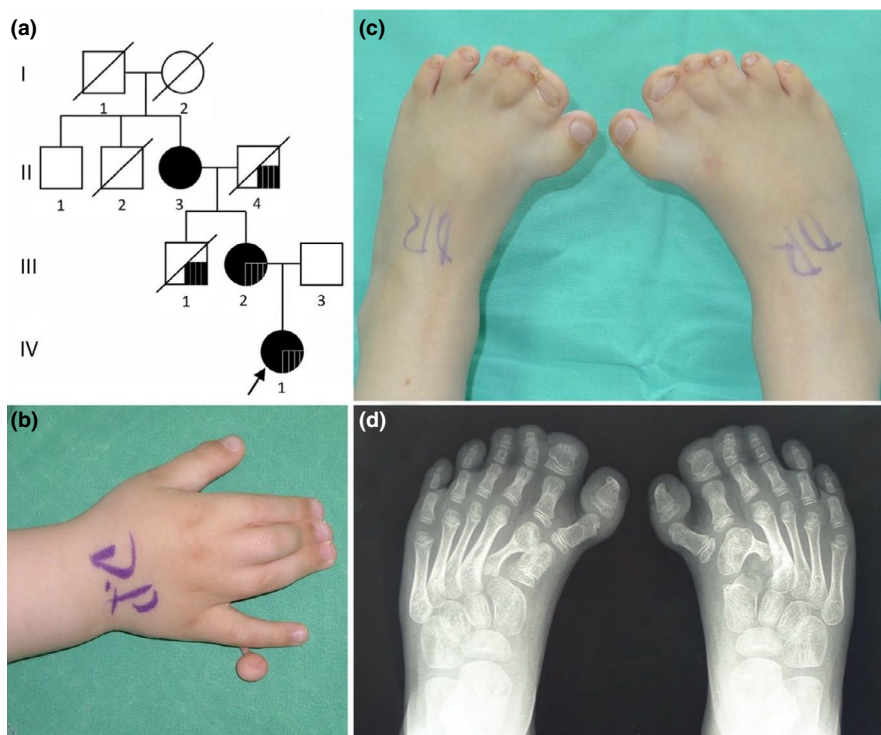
(a) Genealogy of the family. Black symbols denote patients with analyzed variants in *GLI3*. Black square in II-4, III-1, III-2, IV-1 family members denotes congenital chorioretinitis. (b, c) Photographs of hand and feet and (d) X-ray of feet of the patient IV-1 before the surgery at age of 1 year
